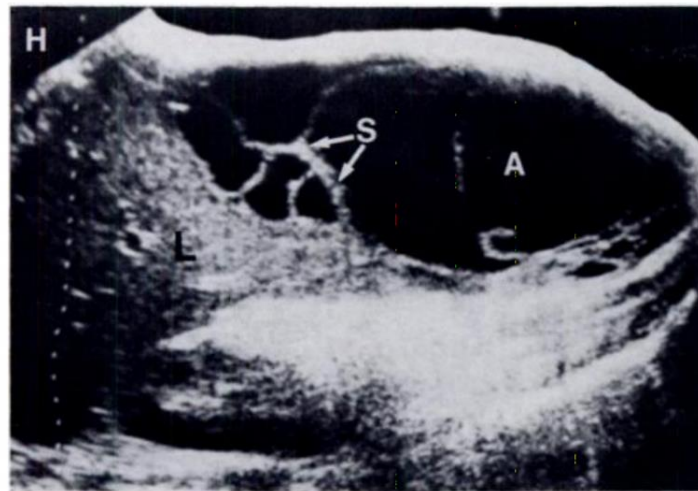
Right longitudinal sonogram in patient with pyogenic peritonitis. Numerous septations (S) within ascitic fluid (A). L = liver, H = head, F = feet.
